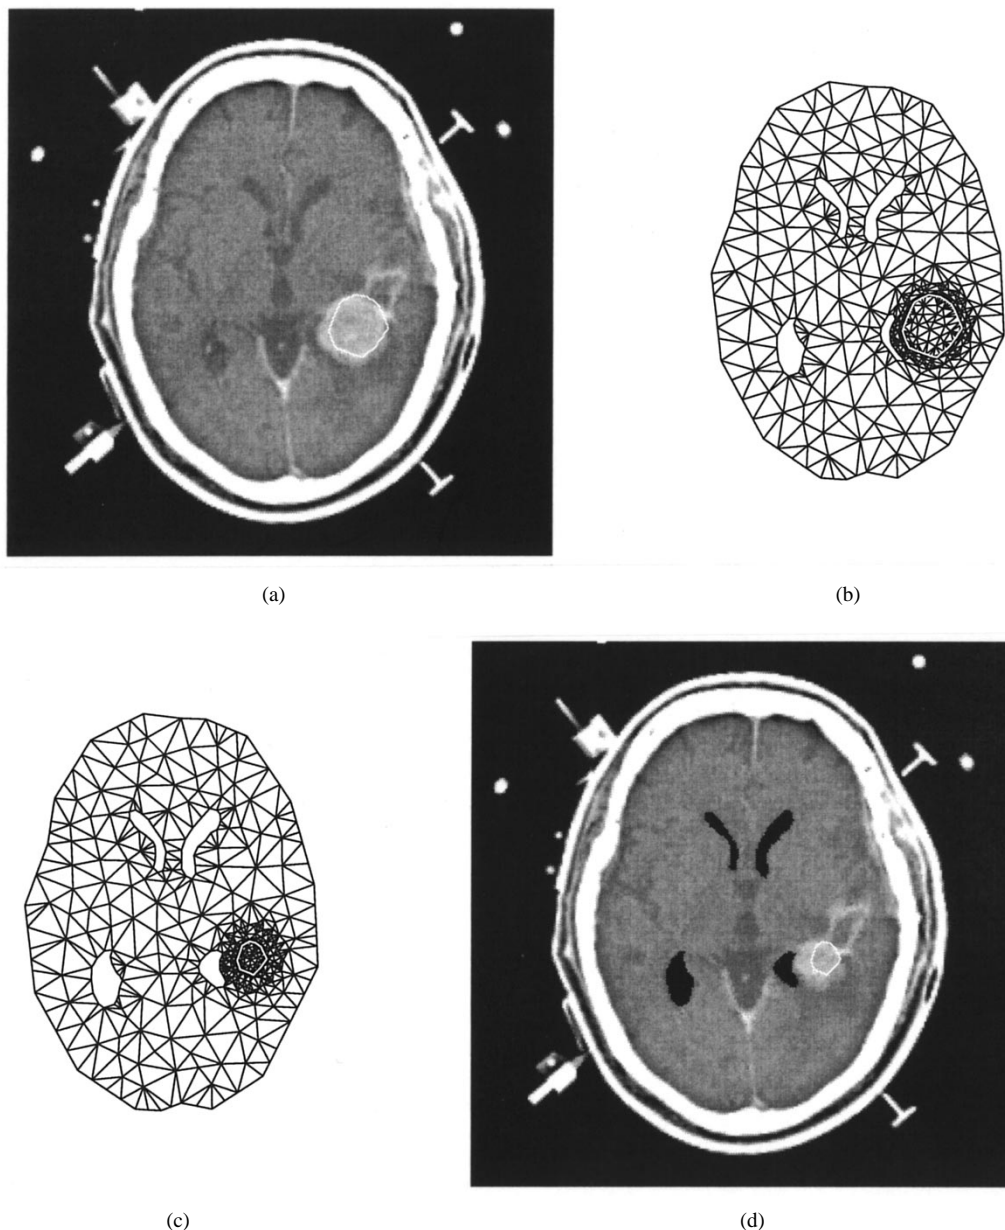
Contraction results for an actual tumor: CT image from a patient (a) with the tumor highlighted. (b) and (c) show the undeformed and deformed finite-element meshes. (d) The image created by deforming the image in panel A based on the finite-element mapping. Note that the slight mismatch between the tumor and its outline in (a) was needed to combat imperfections in our automatic mesh generation scheme, due to the ventricle being very near the tumor.
